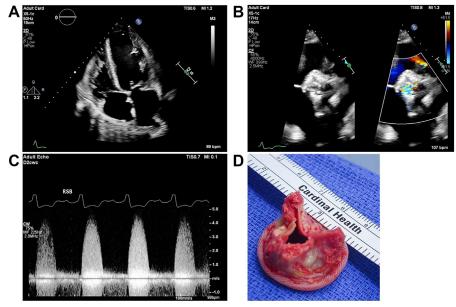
38-year-old with a history of congenital aortic stenosis and two prior cardiac surgeries, most recently with bioprosthetic aortic valve replacement, presented in cardiogenic shock. (*A*) Apical 4 chamber view shows severe left and right ventricular systolic dysfunction. Given progressive cardiogenic shock, she was placed on VA ECMO as a bridge to cardiac surgery. (*B*) Short axis view of the bioprosthetic aortic valve with color compare shows hyperechoic immobile leaflets. (*C*) Continuous wave Doppler from the right upper sternal border (RSB) shows peak and mean gradients of 76 and 44 mm Hg, respectively. (*D*) Given the small annulus and valve, she underwent surgery. The bioprosthetic leaflets were severely calcified and immobile with no signs of infection.
